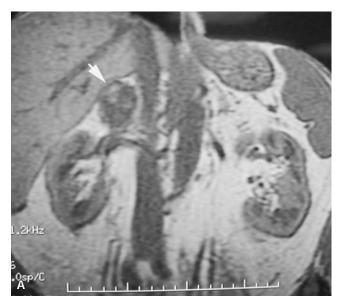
A 64-year-old asymptomatic man had routine abdominal magnetic resonance imaging during a routine physical examination. *A*, The right adrenal tumor is heterogeneous and measured $4.3 \text{ cm} \times 4.2 \text{ cm} \times 3.5 \text{ cm}$ (*white arrow*). The left adrenal gland is normal. Biochemical workup showed no hyperfunction. He underwent a laparoscopic adrenalectomy. *B*, Pathology showed a 5 cm adrenal cortical adenoma. The tumor was morsellated for removal. The adenoma appears golden-yellow.
